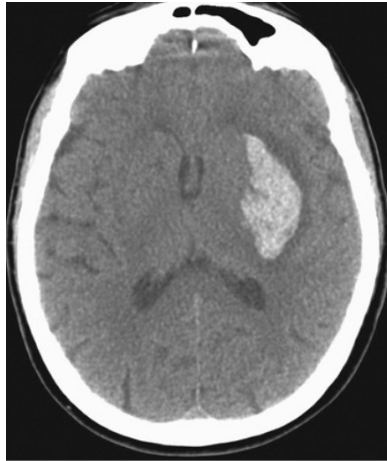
CT IMAGING OF INTRACEREBRAL HEMORRHAGE
